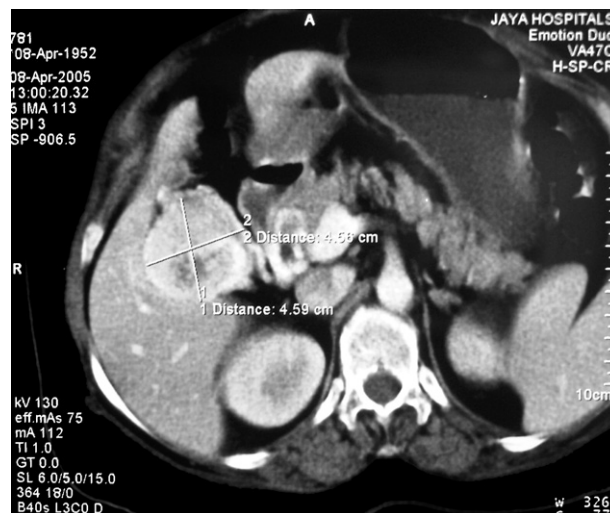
Contrast-enhanced computed tomography scan of the abdomen shows a large intensively enhancing mass lesion in the gallbladder fossa with areas of necrosis.
